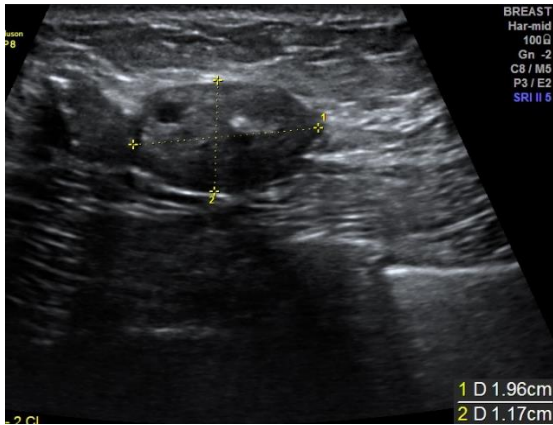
44 years old female with Fibroadenoma. Transverse sonographic image, showing an oval shape, hypoechoic mass with thin echogenic capsule.
